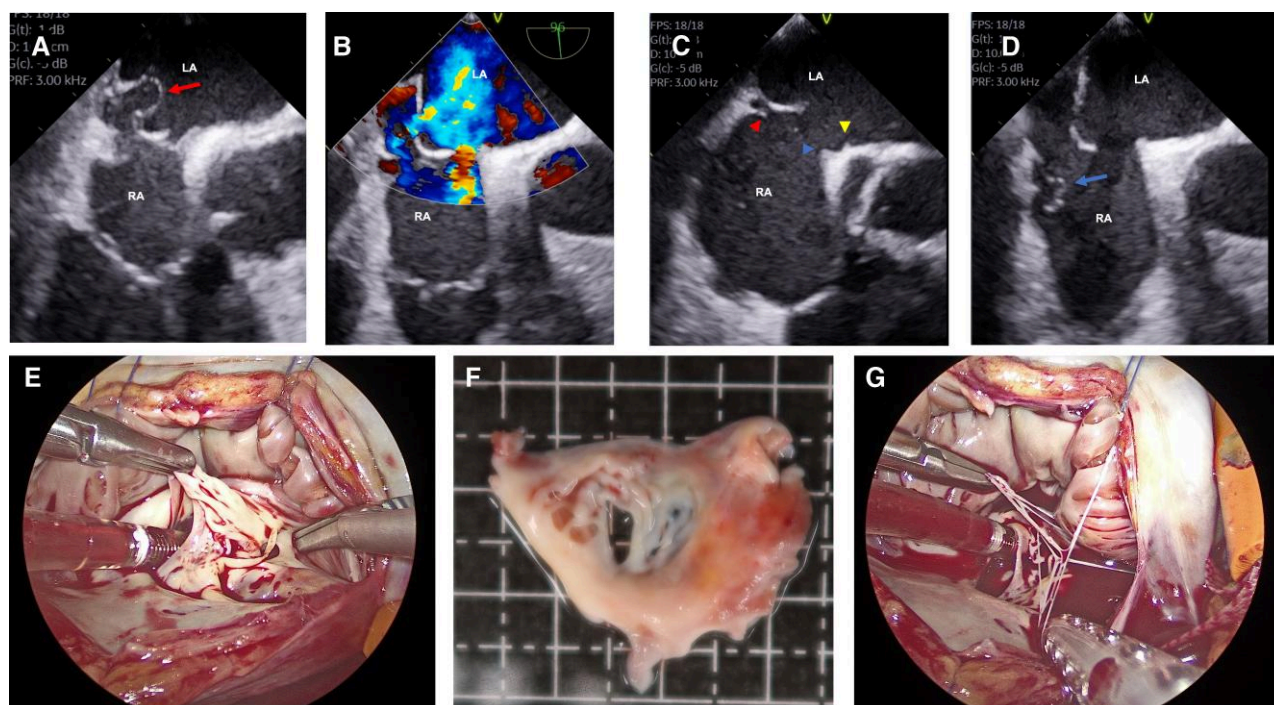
Transoesophageal echocardiography and perioperative findings. (A) Large mobile atrial septal aneurysm (red arrow), (B) multiple defects of atrial septum. (C) double atrial septum; septum primum (yellow arrowhead); septum secundum (red and blue arrowheads). (D) Chiari network (blue arrow). (E) Atrial septal defect and multi-fenestrated atrial septal aneurysm. (F) Multi-fenestrated atrial septal aneurysm. (G) Chiari network. LA, left atrium; RA, right atrium.
